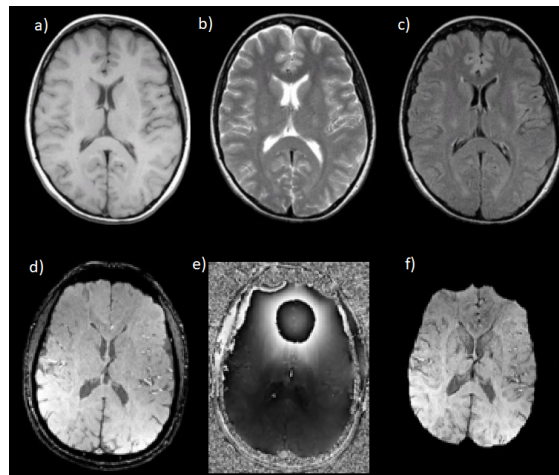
Transverse brain plane. Sequences in first row [118]: T1W (a), T2W (b), FLAIR (c); in second row [117]: Magnitude (d), Phase (e), SWI (f).
